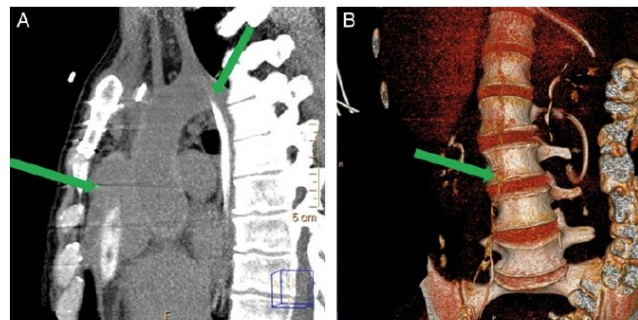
(A) Arrows point to the thoracic duct and collection of contrast fluid in the mediastinum. (B) Computed tomography lymphangiography (3D reconstruction), arrow points to the thoracic duct.
